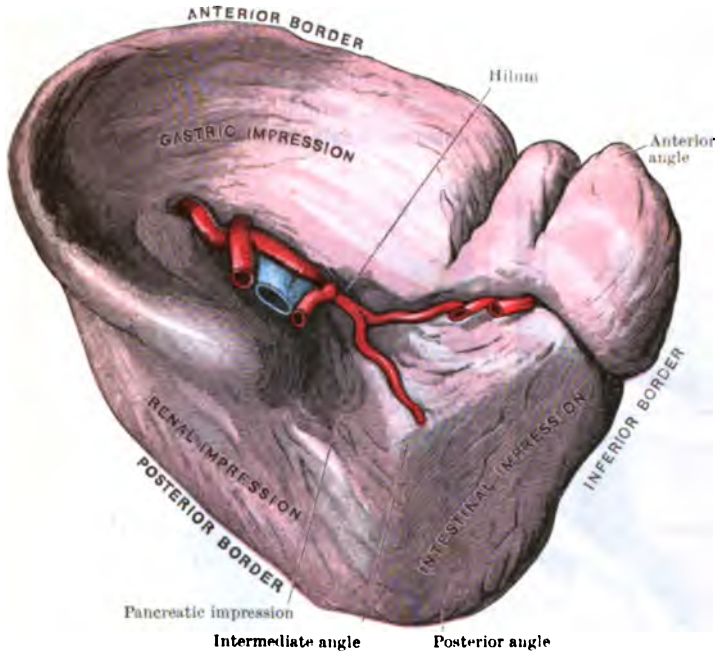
THE SPLEEN—VISCERAL ASPECT.
